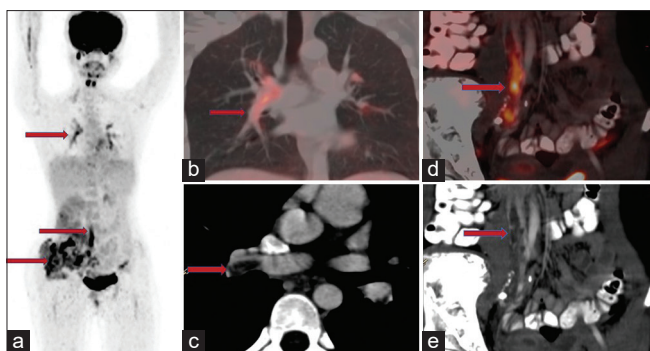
(a) Maximum intensity projection image showing FDG avid lesions in right hemipelvis, linear uptake along abdomino-pelvic region and branching uptake from bilateral lung hila (red arrows). (b) FDG PET/CECT fusion image sagittal section showing FDG avid filling defect in bilateral pulmonary artery tracking along lobar and interlobar branches (arrow), (c) CECT chest axial imaging showing contrast filling defect in bilateral pulmonary arteries, (d) FDG PET/CECT fusion image sagittal section showing FDG avid filling defect tracking from left iliac vein to IVC (arrow), seen as filling defect on CECT (e-arrow) image
